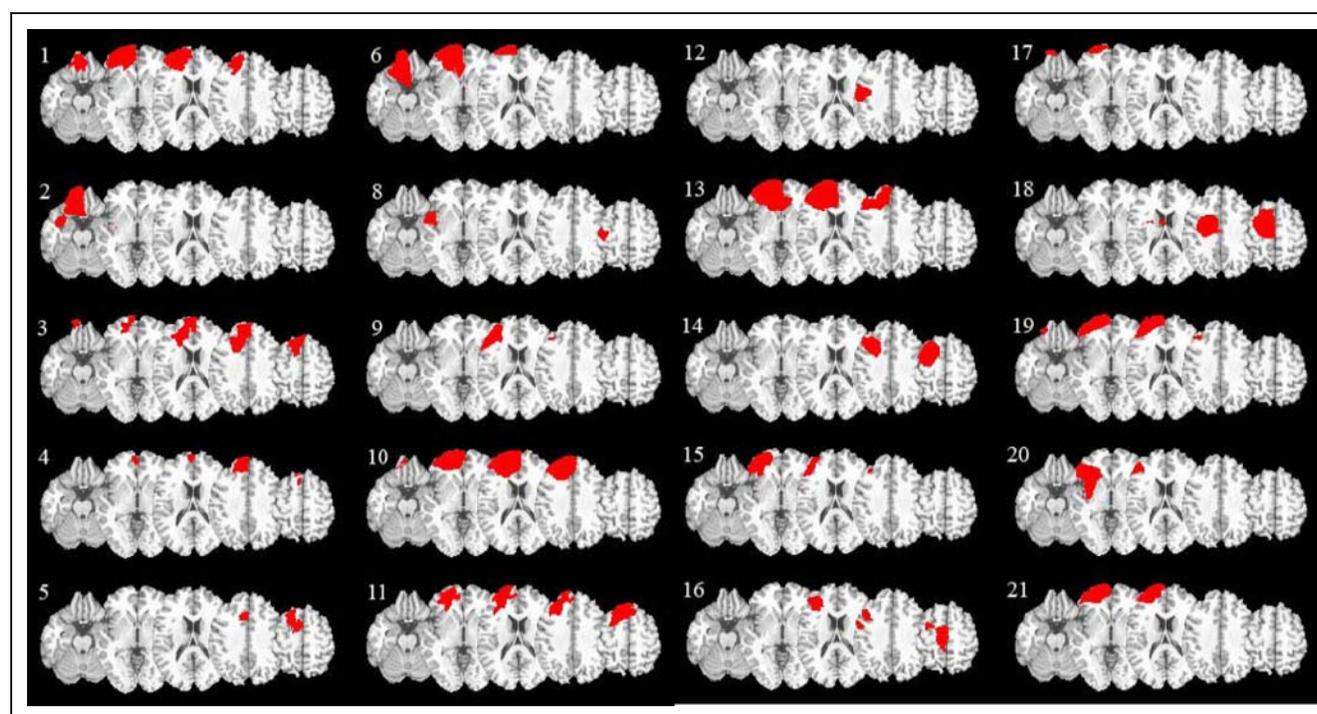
MR or CT images for each patient normalized to the MRIcro template. Shading shows lesion in the right frontal lobe for each patient (note that Patient 7 discontinued participation). Reprinted from Davidson, Gao et al. (2008) by permission of Taylor & Francis, Ltd. (<http://www.informaworld.com>).
